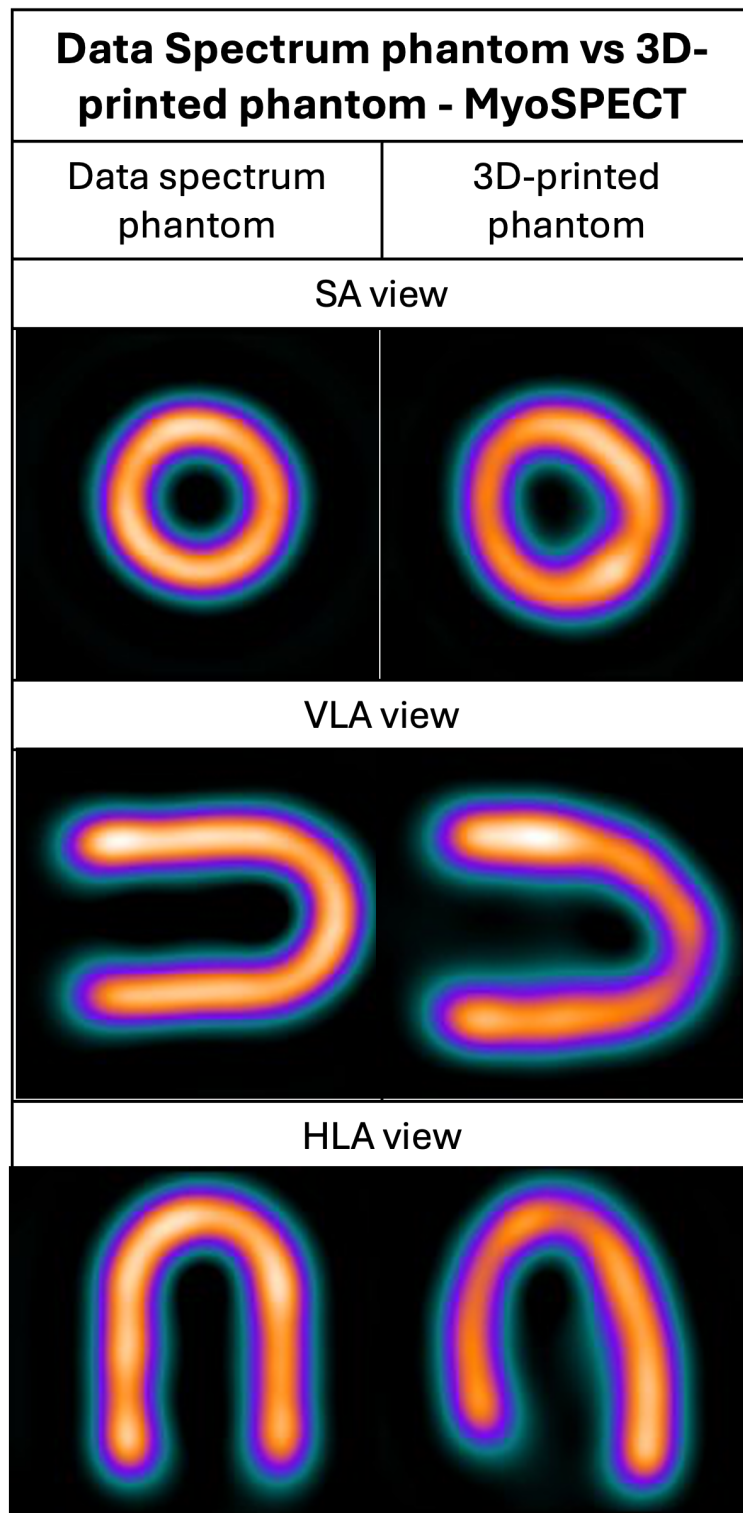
SA, VLA and HLA views obtained through imaging with MyoSPECT
